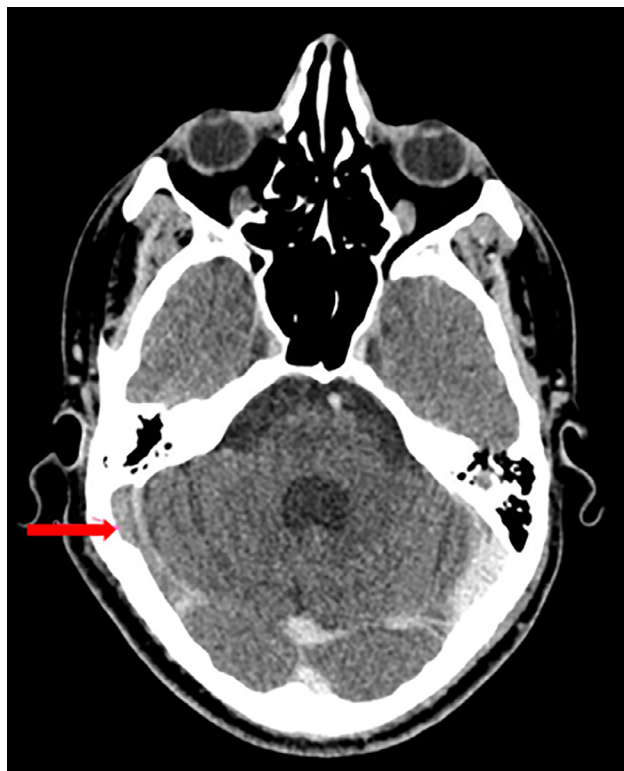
Brain CTA showing thrombosis of the right transverse sinus.
